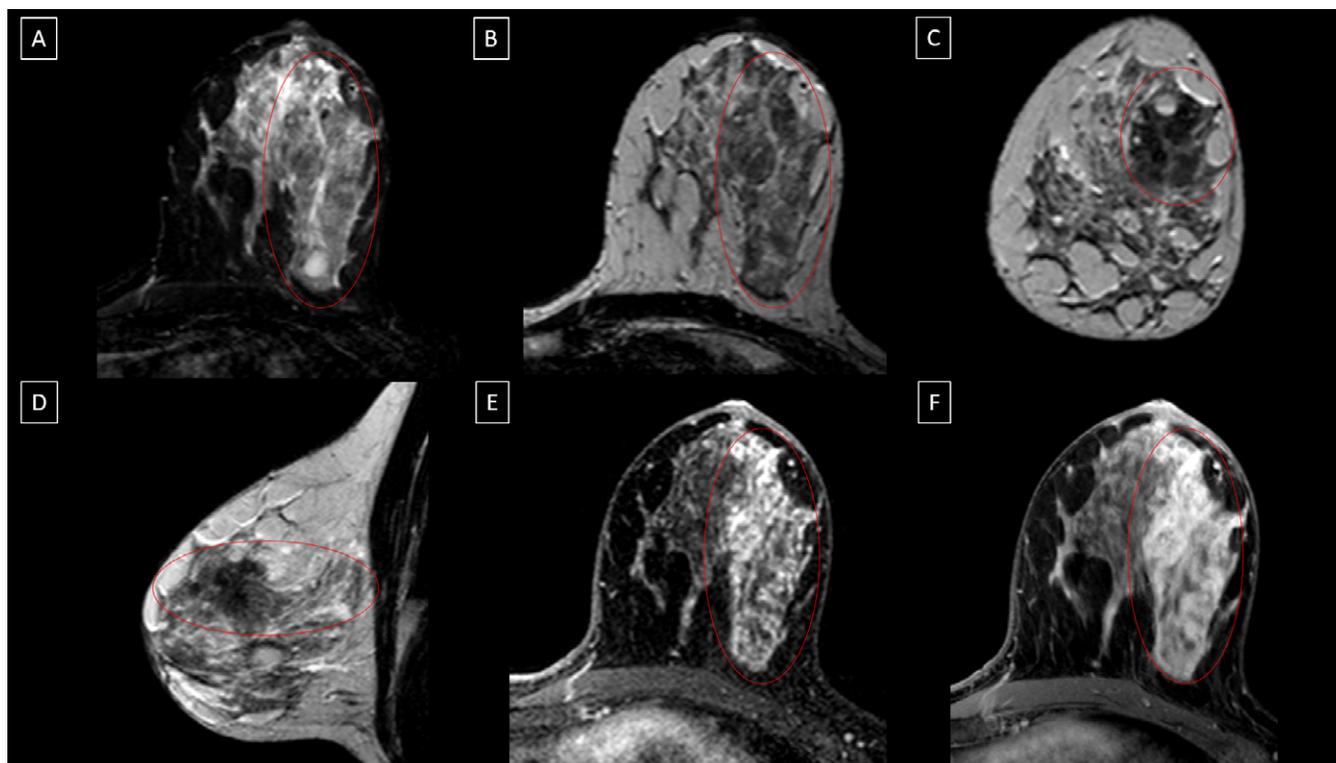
A female patient presenting with bloody nipple discharge from the left breast underwent diagnostic contrast-enhanced breast MRI. The diagnostic MRI revealed suspicious heterogeneous segmental non-mass enhancement with a plateau dynamic curve in the upper-outer quadrant of the left breast. Subsequent core-needle biopsy under ultrasound guidance confirmed ductal carcinoma in situ. The imaging series comprised an axial short-tau inversion recovery image (A), axial T-2 image (B), coronal T-2 image (C), sagittal T-2 image (D), axial contrast-enhanced T-1fs THRIVE image (E), and axial T-1fs delayed high-resolution THRIVE image (F). The segmental non-mass enhancement was consistently demarcated with a red oval across all images.
